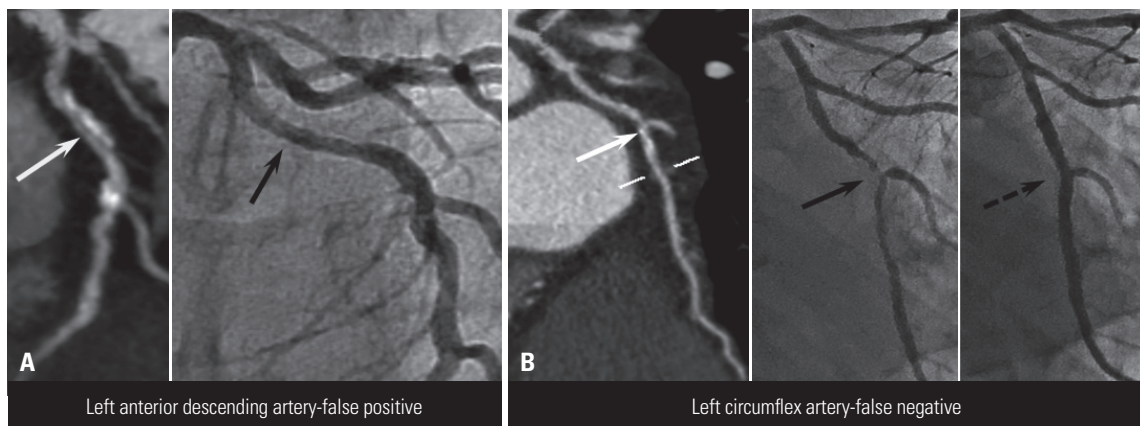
Example of discordance between the coronary computed tomographic angiography (CCTA)-indicated therapy and the actual conducted therapy. Panel (A) and (B) are the CCTA and conventional coronary angiography images, respectively, from the same patient. (A) This patient was originally referred for need of revascularization of the left anterior descending artery based on the CCTA images (white arrow); however, revascularization was not performed (black arrow). Right image is CCTA and left image is conventional coronary angiography. (B) The same patient actually underwent revascularization of the left circumflex artery, which was not originally indicated based on CCTA images (white arrow); however, revascularization was performed (black arrow with solid line, before revascularization; black arrow with dotted line, after revascularization). Right image is CCTA, and middle and left images are conventional coronary angiography (before and after percutaneous coronary intervention, respectively).
